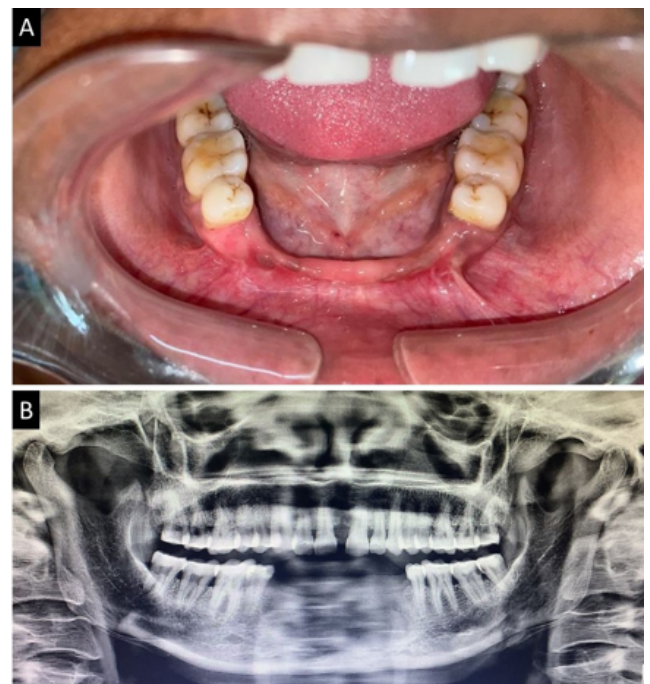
6-month post-surgical follow-up showing A: Adequate healing without evidence of disease on; A: Clinical inspection, and B: Orthopantomogram.
